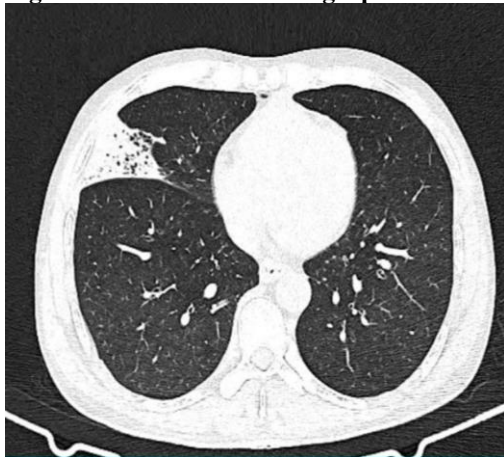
Axial HRCT Thorax Showing Right Middle Lobe, Lateral Segment Wedge Shaped Opacity
